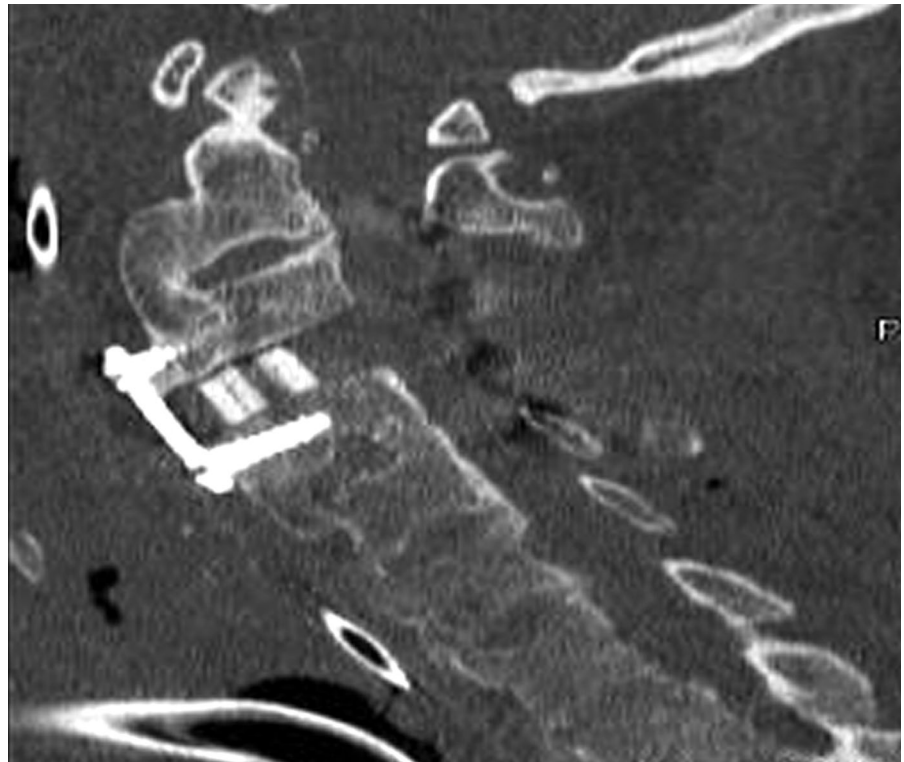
Postoperative sagittal CT scan of the cervical spine shows the decompressed central canal, anterior C3-C4 cervical discectomy with allograft and plate, and posterior decompressive laminectomy at C3 and C4.
